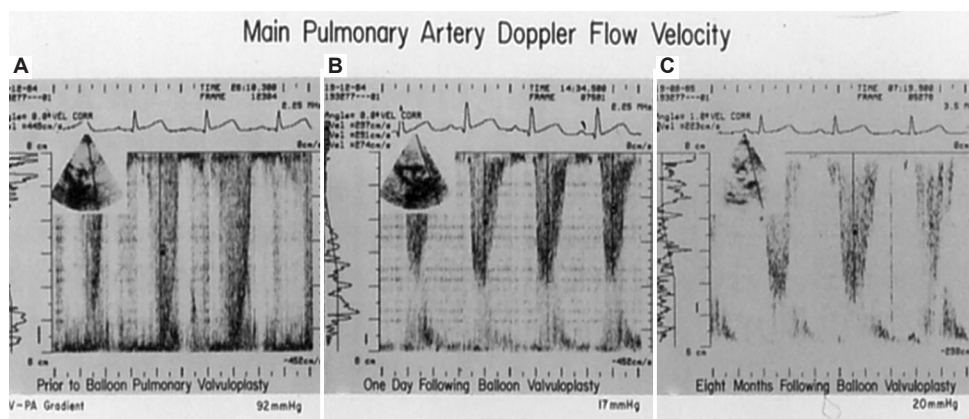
Examples of Doppler studies before (A), the next day following (B), and 8 months following (C) balloon pulmonary valvuloplasty (BPV) demonstrating a reduction in Doppler peak instantaneous gradient from 92 mmHg (A) to 17 mmHg on the day after (B) and to 20 mmHg 8 months (C) after BPV. Reproduced from Rao.⁵²
